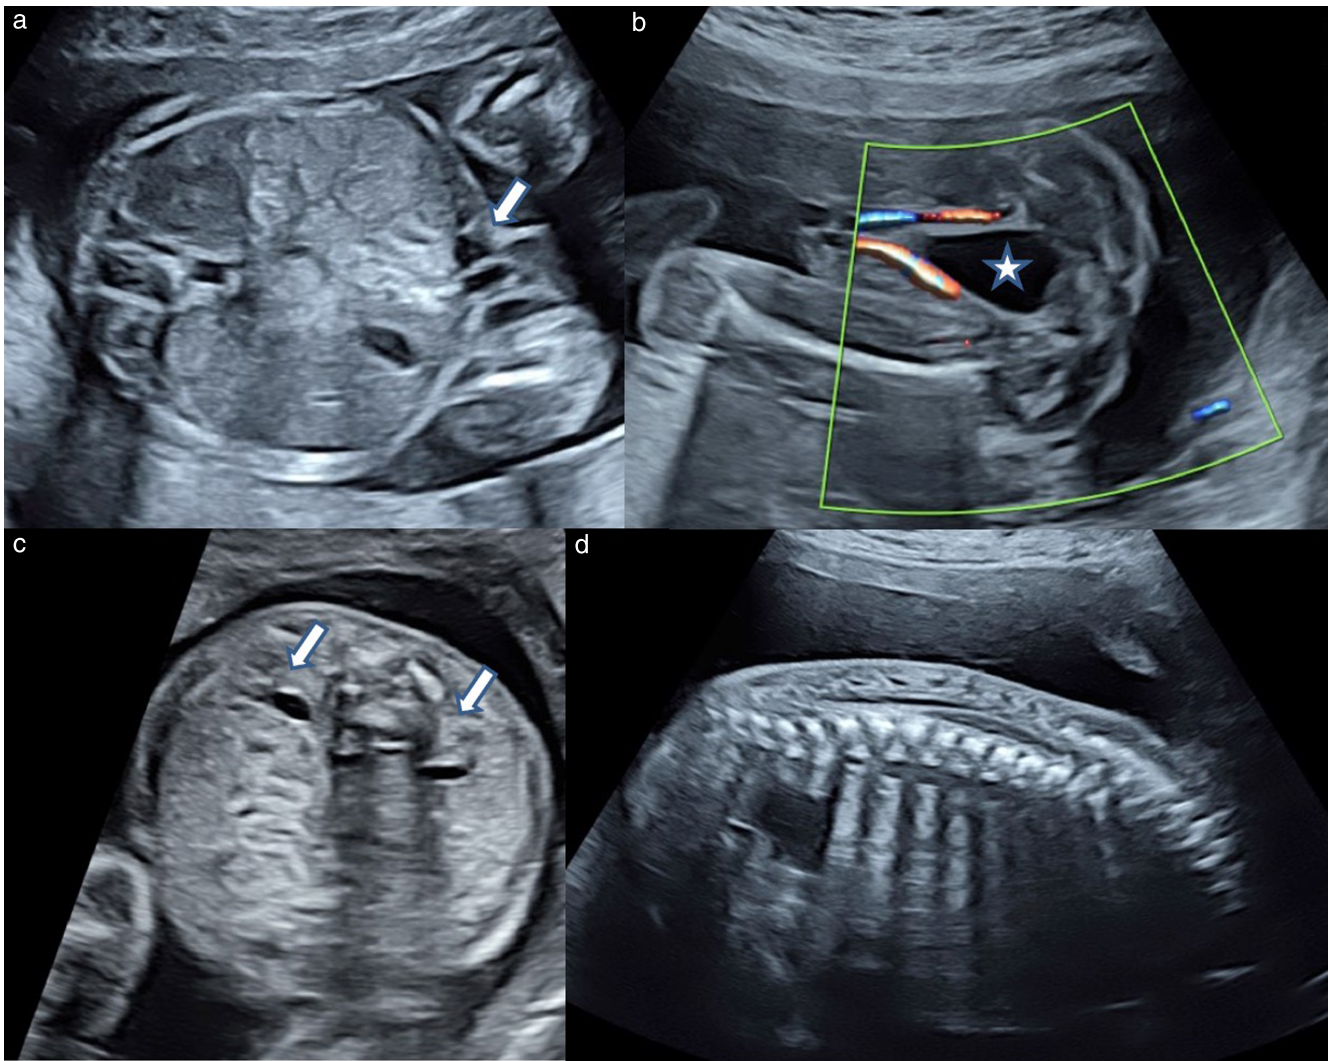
Ultrasound imaging of the fetal cord insertion site and bladder, with umbilical arteries, kidneys and spine. The umbilical cord insertion site into the fetal abdomen (a, arrow) provides information about the presence of ventral wall defects, such as omphalocele or gastroschisis. The fetal bladder (b, ☆) and both kidneys (c, arrows) should be identified. Axial and longitudinal views of the spine (c,d) including a clearly visible intact skin line provide effective screening for spina bifida, especially when these scanning planes are abnormal in the presence of frontal skull deformation and an obliterated cisterna magna.
